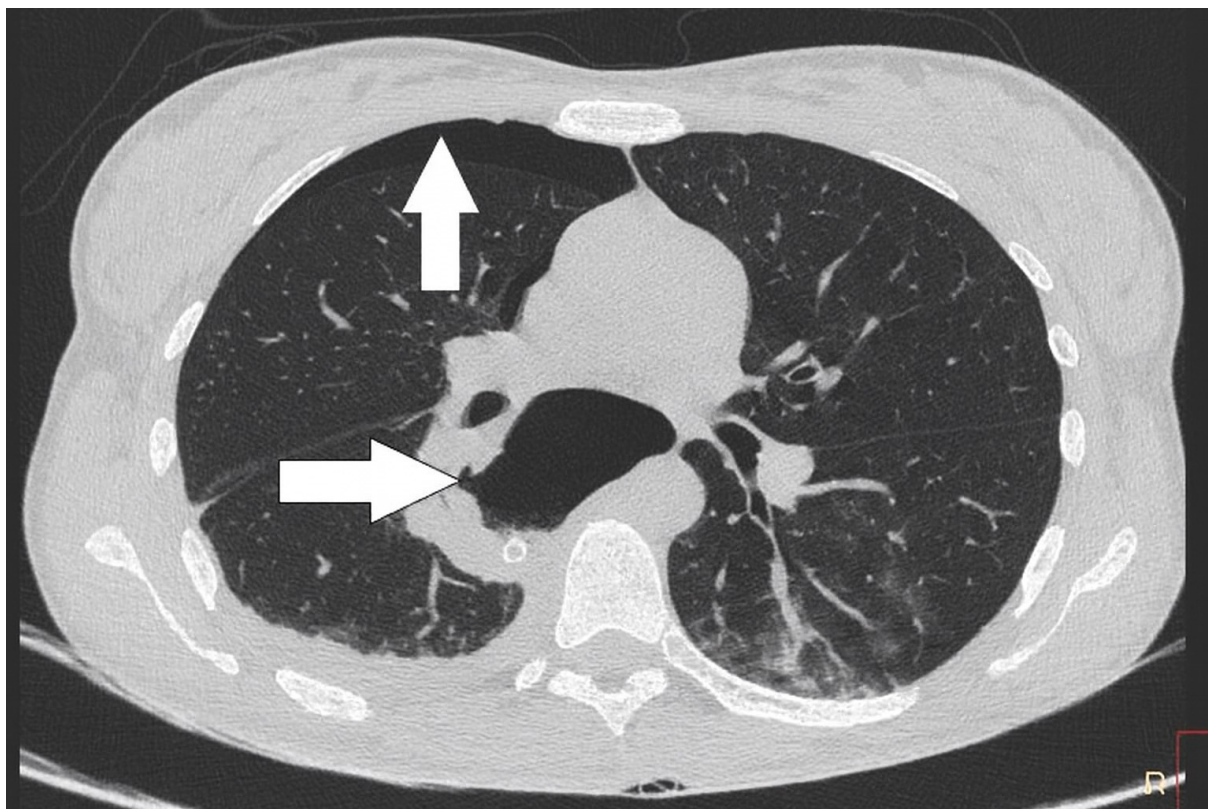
Patient C1, native chest CT on the day of POEM procedure, axial plane, lung window. Defect in the esophageal wall (horizontal arrow) after perforation at the level of the mucosal incision and right-sided pneumothorax (vertical arrow).
